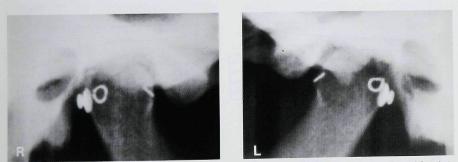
Orthopantomogram of the right (R) and left (L) condylar regions with markers on the lateral (straight wire), medial (looped wire), and posterior pole (orthodontic button) of the condylar head.
